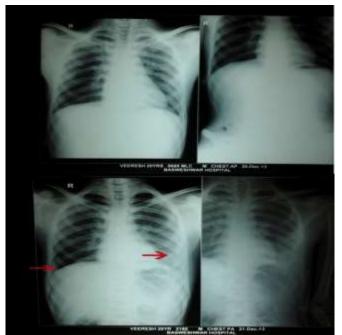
Chest Xray and Xray Erect abdomen on presentation and after 36 hours showing gas under diaphragm and left hemothorax.
